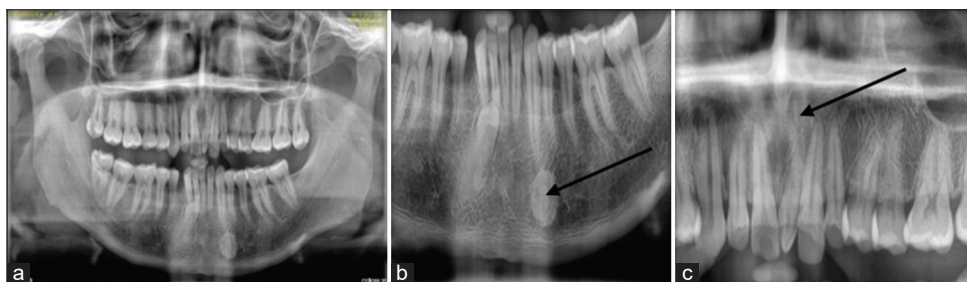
(a) Orthopantomogram (OPG); (b) OPG showing odontome; (c) OPG showing mesiodens (case 2)
